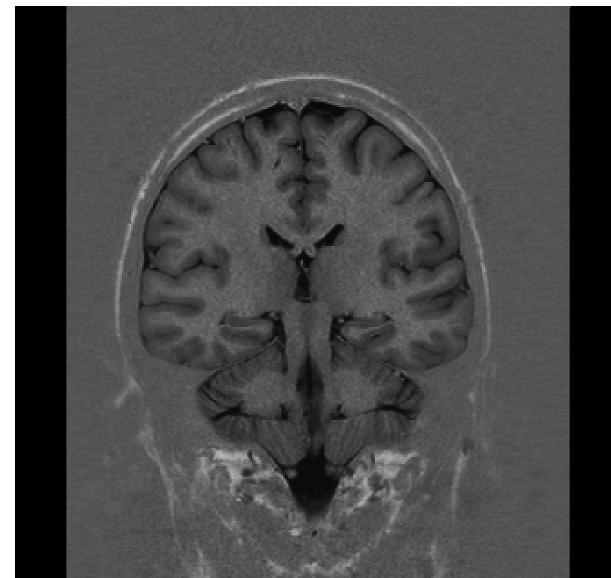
MRI image of the head Sets of images may be acquired for 1 mm-section thickness at 2 mm apart for diagnosis of the entire volume of the brain. (Photo courtesy of Siemens Medical.)
